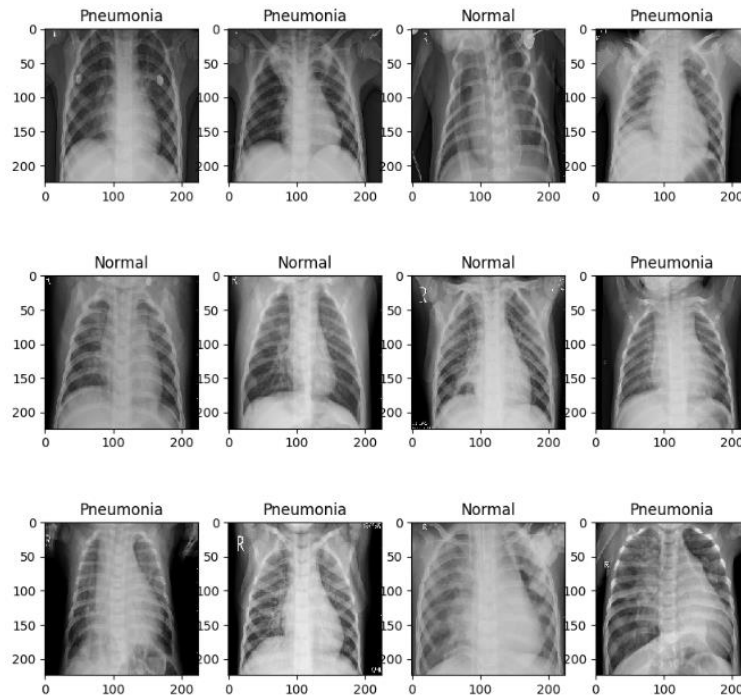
Derived sample images from chest X-ray datasets.
